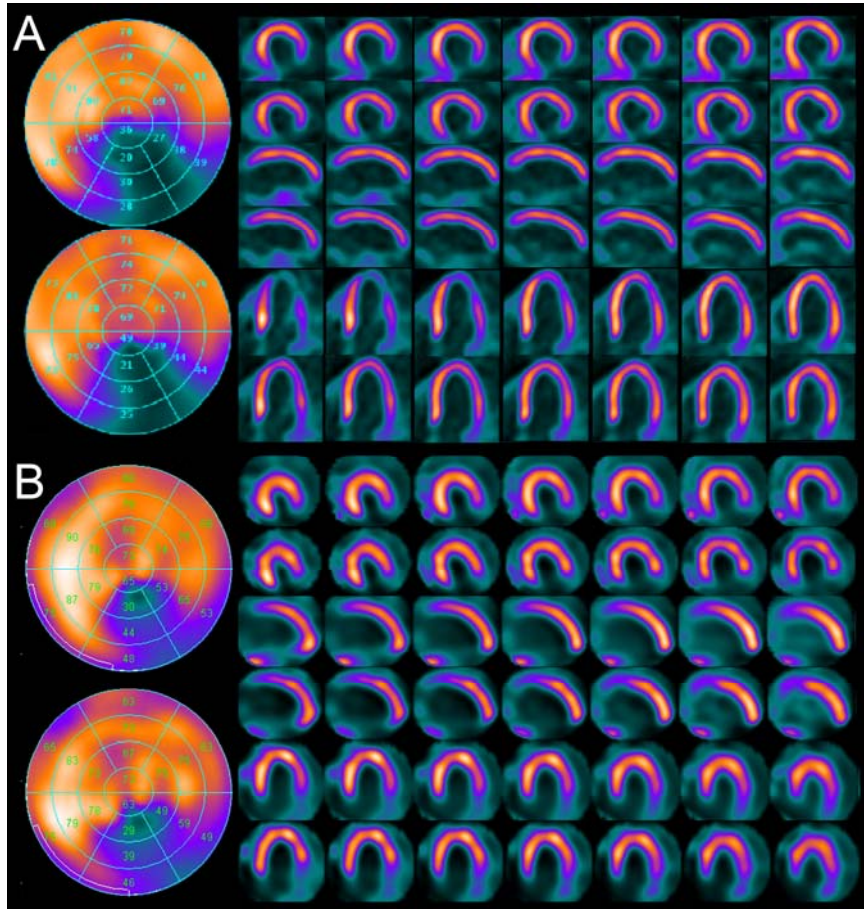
Static ^{99m}Tc -tetrofosmin cadmium zinc telluride SPECT (A) and ^{13}N -ammonia PET (B) images acquired during stress (top rows) and at rest (bottom rows). Images were obtained from the same patient as in Figure 1.
